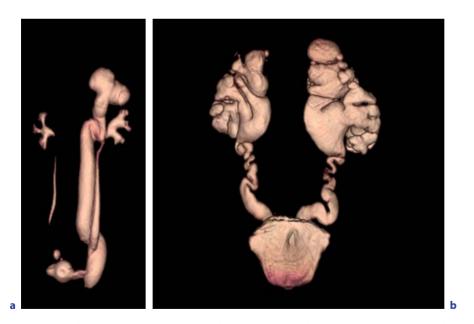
Volume-rendered T2-weighted images. a Volume-rendered T2 images of duplex system with poorly functioning and obstructed upper pole moiety. Despite minimal excretion of contrast agent, anatomic images of the duplex system can be obtained that show the ectopic insertion of the upper pole ureter. b Volume-rendered T2 images of poorly functioning hydronephrotic kidneys in a boy with posterior urethral valves. Even with poor renal function exquisite anatomical images are easily obtained
